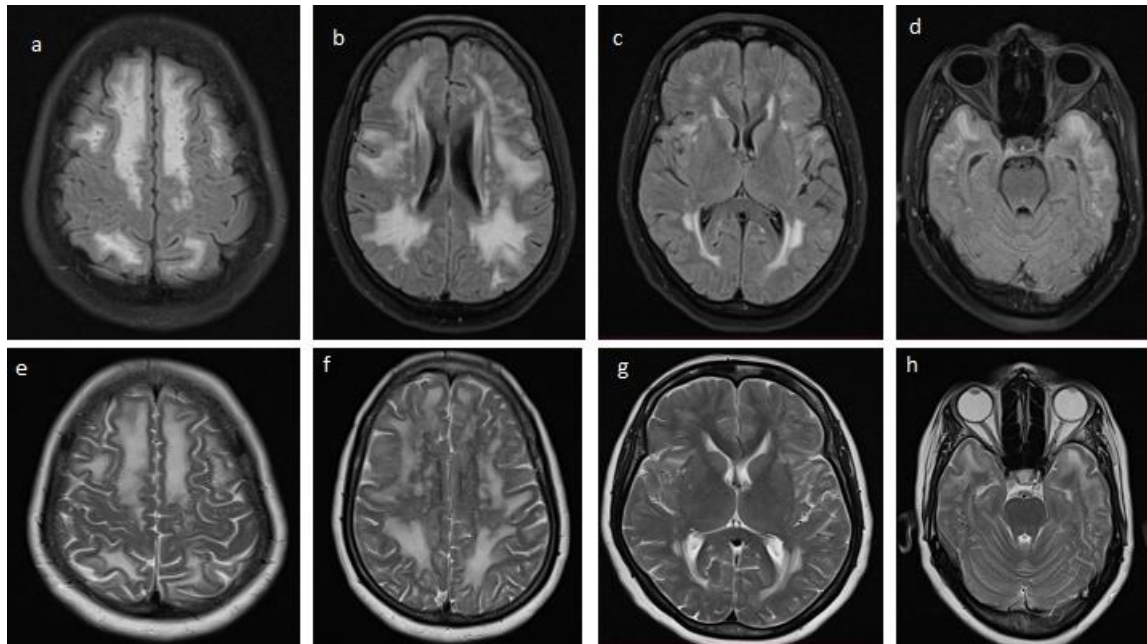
MRI Brain axial (a to d) - FLAIR sequences and (e to h) - T2 weighted sequences
